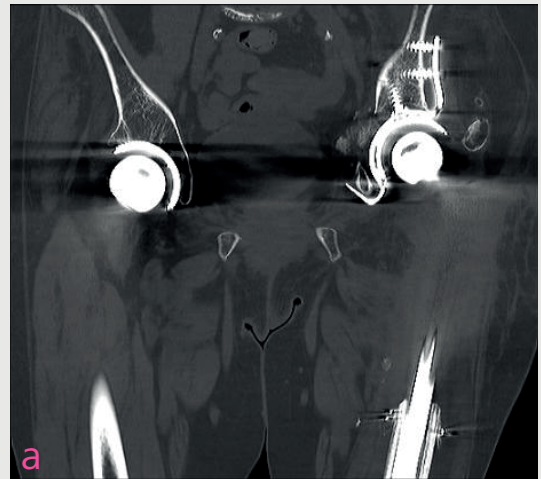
Postoperative CT imaging in the frontal plane (a) and sagittal plane (b, c)
